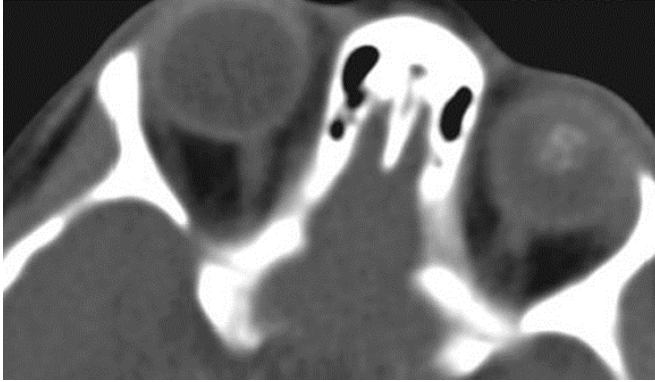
Patient L, 33 months old, non-contrast computed tomography fragment
